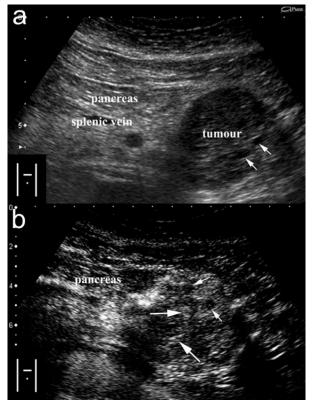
Serous cystadenoma at conventional (a.) and echo-enhanced sonography (b.). a. Tumor at the pancreatic tail with small cystic areas (small arrows) and thin fibrotic strands. b. Highly vascularized tumor arteries (large arrows) along the fibrotic strands.
